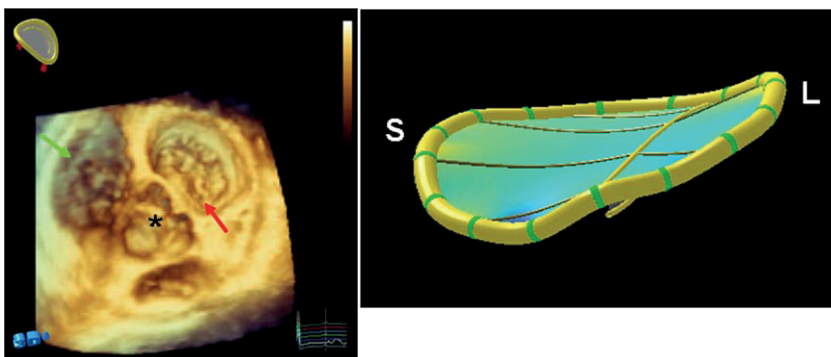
3-Dimensional Echocardiographic Reconstruction of the Left Atrioventricular Junction. (Left) Three-dimensional echocardiographic reconstruction of the left atrioventricular junction, demonstrating the location of the mitral valve (red arrow) relative to the aortic valve (*). The green arrow indicates the right ventricle. (Right) Saddle-shaped appearance of the mitral atrioventricular junction or “annulus.” Note the elevated septal (S) and lateral (L) segments and complementary depressed segments along the central zone of apposition.
